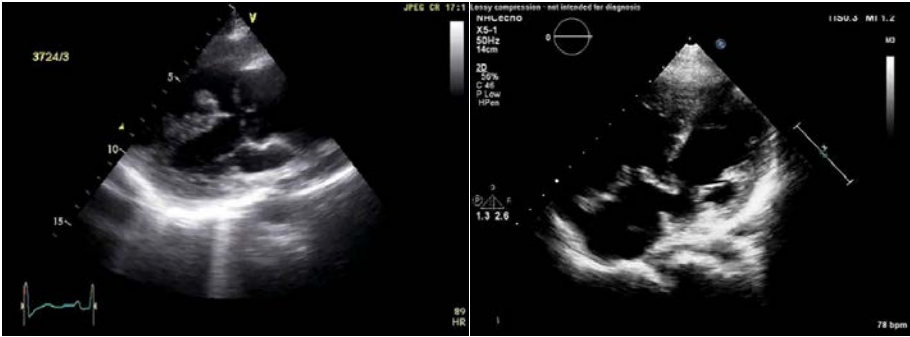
Tetralogy of Fallot, previously undiagnosed in a young male, necessitating surgical correction. The transthoracic echocardiogram demonstrates the malalignment VSD, overriding aorta and right ventricular hypertrophy.
